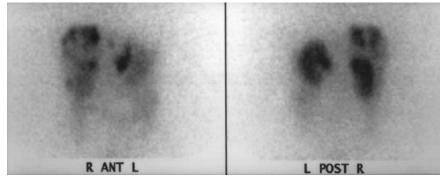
¹¹¹In-DOTATOC scintigram of abdomen of 43-y-old woman with recurrence of EPT and multiple liver metastases before DOTATOC treatment. ANT = anterior; POST = posterior.
